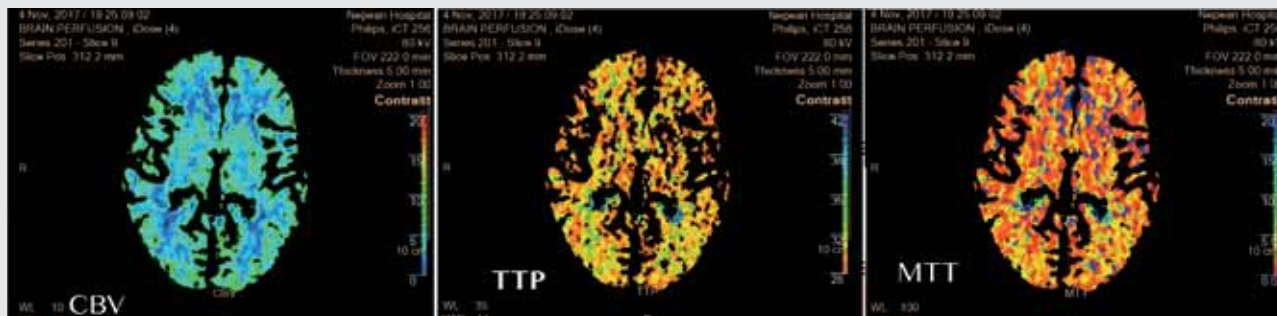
Cerebral CT perfusion scan totally normal
